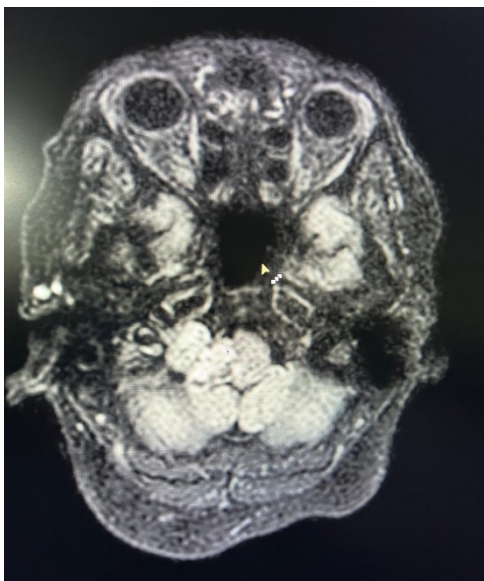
Coronal contrast-enhanced MRI showing a multilobulated right jugular foramen mass with mild compression of the medulla, suggestive of a vagal nerve schwannoma.
